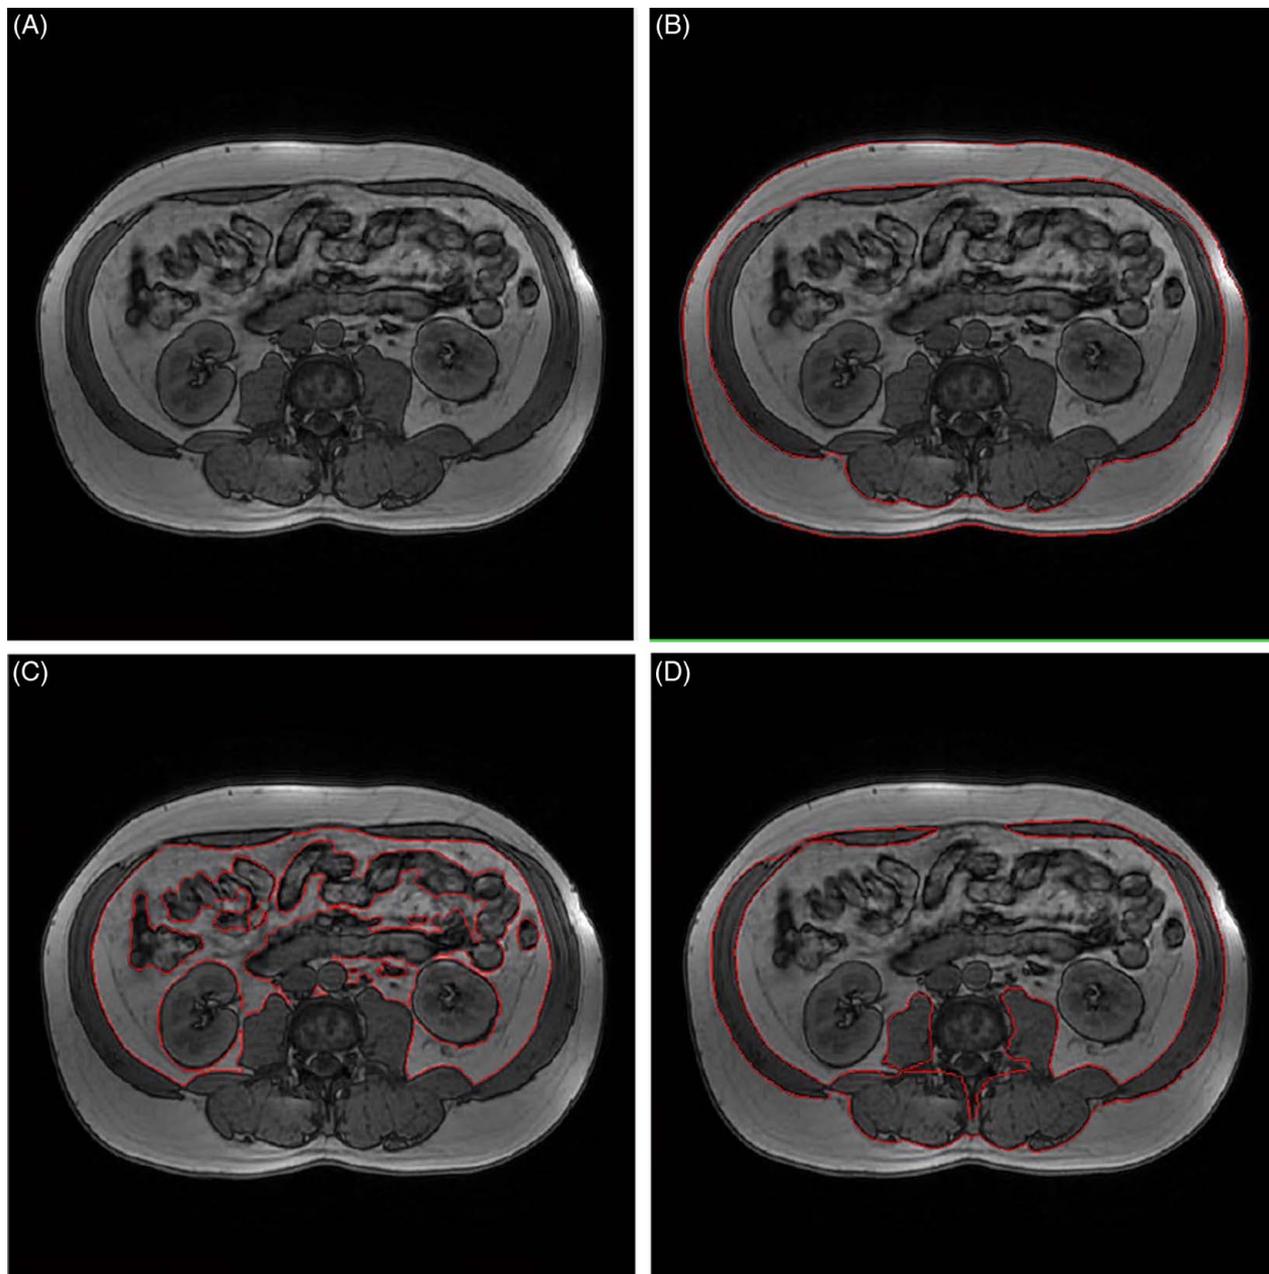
(A) MRI without contour. (B) Contour of subcutaneous adipose tissue. (C) Contour of visceral adipose tissue. (D) Contour of skeletal muscle.
